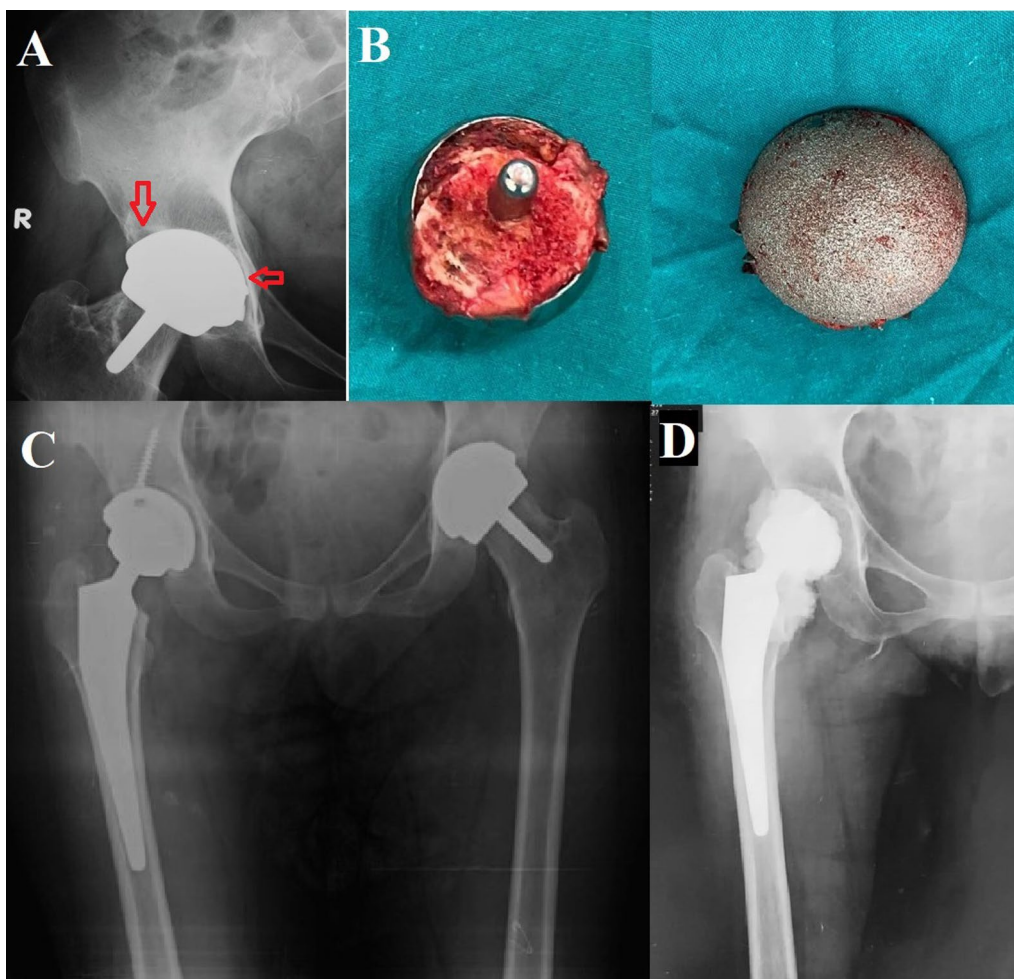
Revision surgeries performed for the patient. A Right hip plain radiograph showing radiolucent lines around the acetabular component (red arrows). B An image of the hip resurfacing implants after being removed during the first revision surgery shows the acetabular component's clear back surface. C Cementless THA implanted at the first revision surgery. D After diagnosing PJI, the first-stage THA cement spacer was performed with the stem left in place, and a cement ball was inserted in the acetabulum
